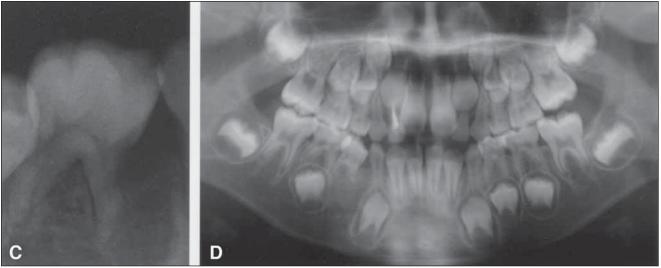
Clinical intraoral views (a, b) and radiographic appearance (c, d) at 7 years, 7 months old after treatment. Panoramic radiograph taken at 11 years old (e).
